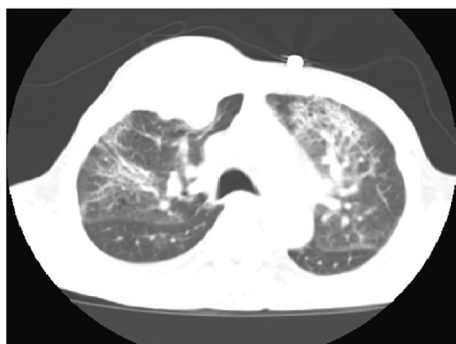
Chest CT showing bilateral patchy alveolar and interstitial opacities, affecting primarily the upper lobes.
